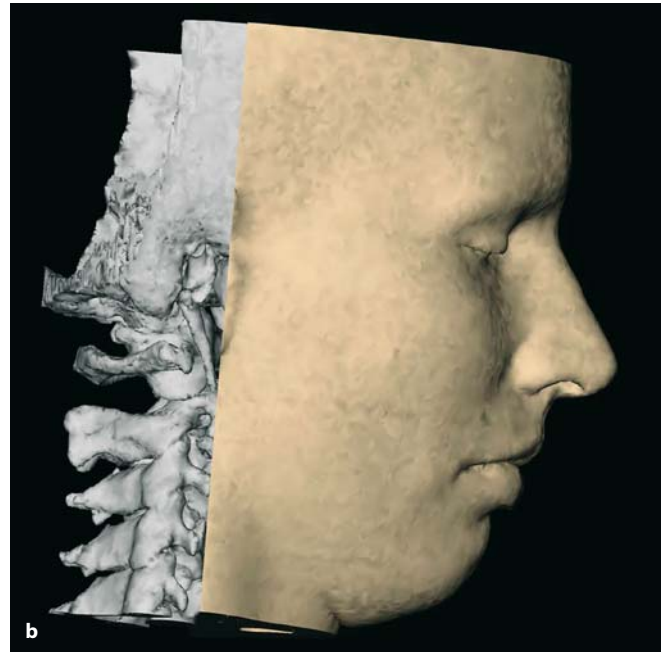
a,b. Lateral view (patient K.C.). In order to compute the virtual lateral X-ray, the skull is virtually positioned in the right profile view with the cantho-meatal or trago-canthal line (the line that extends from the external acoustic meatus or tragus to the lateral junction of the eyelids) parallel to the horizontal plane
